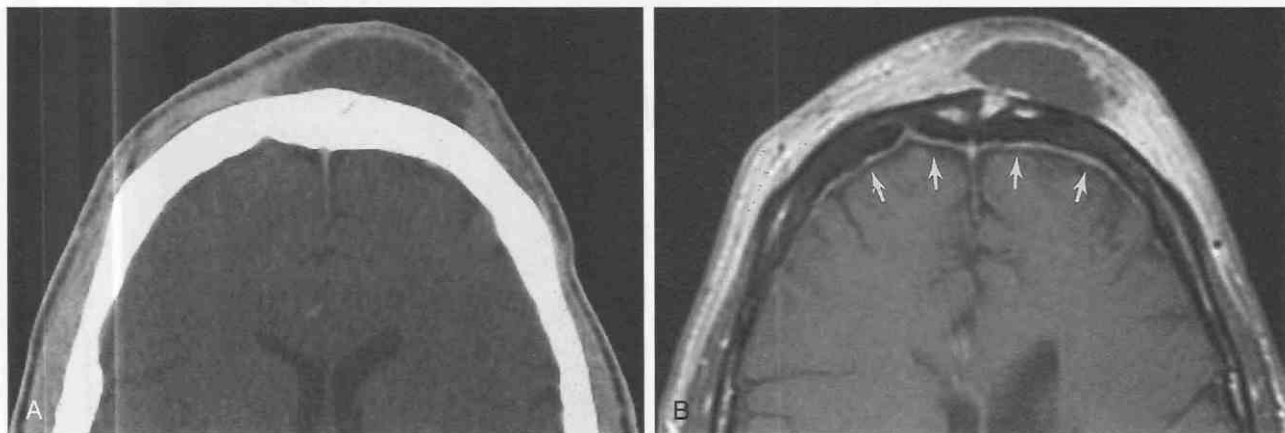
Superior sensitivity of MRI over CT in detection of meningeal disease: Pott's puffy tumor. *A*, Enhanced axial CT image at the level of an extracranial subperiosteal collection of pus. *B*, Enhanced axial MR image obtained after administration of gadolinium at the same level shows enhancement of the subjacent dura/arachnoid (arrows). Detection of this meningeal enhancement prompted a change of antibiotics to improve cerebrospinal fluid drug penetration.
